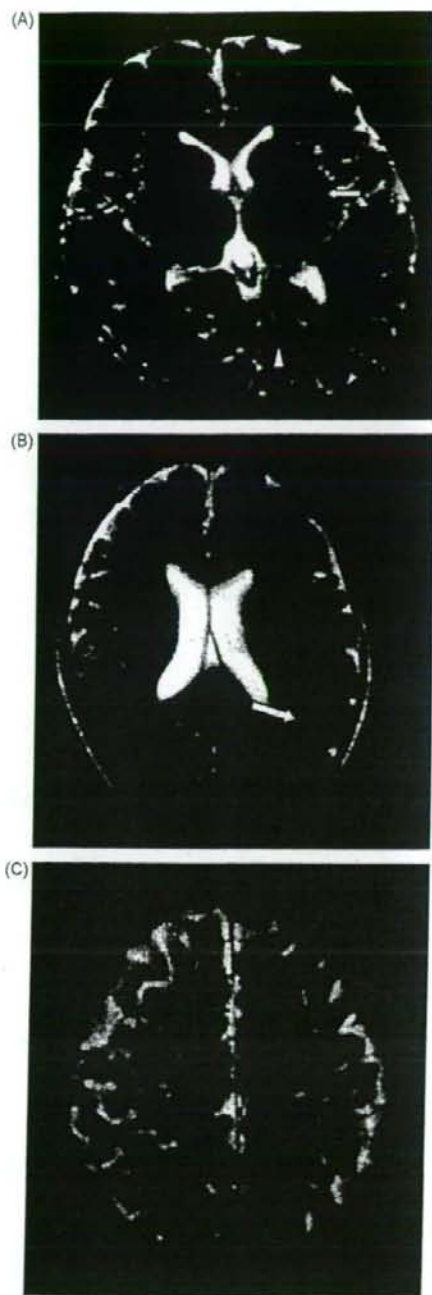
(A) Depiction of regions of interest (T2-weighted images). Black arrow indicates Broca's area; white arrow indicates arcuate fasciculus; black arrowhead indicates auditory cortex; white arrowhead indicates visual cortex. (B) Black arrow indicates Wernicke's area; white arrow indicates angular gyrus. (C) Arrow indicates motor cortex.
